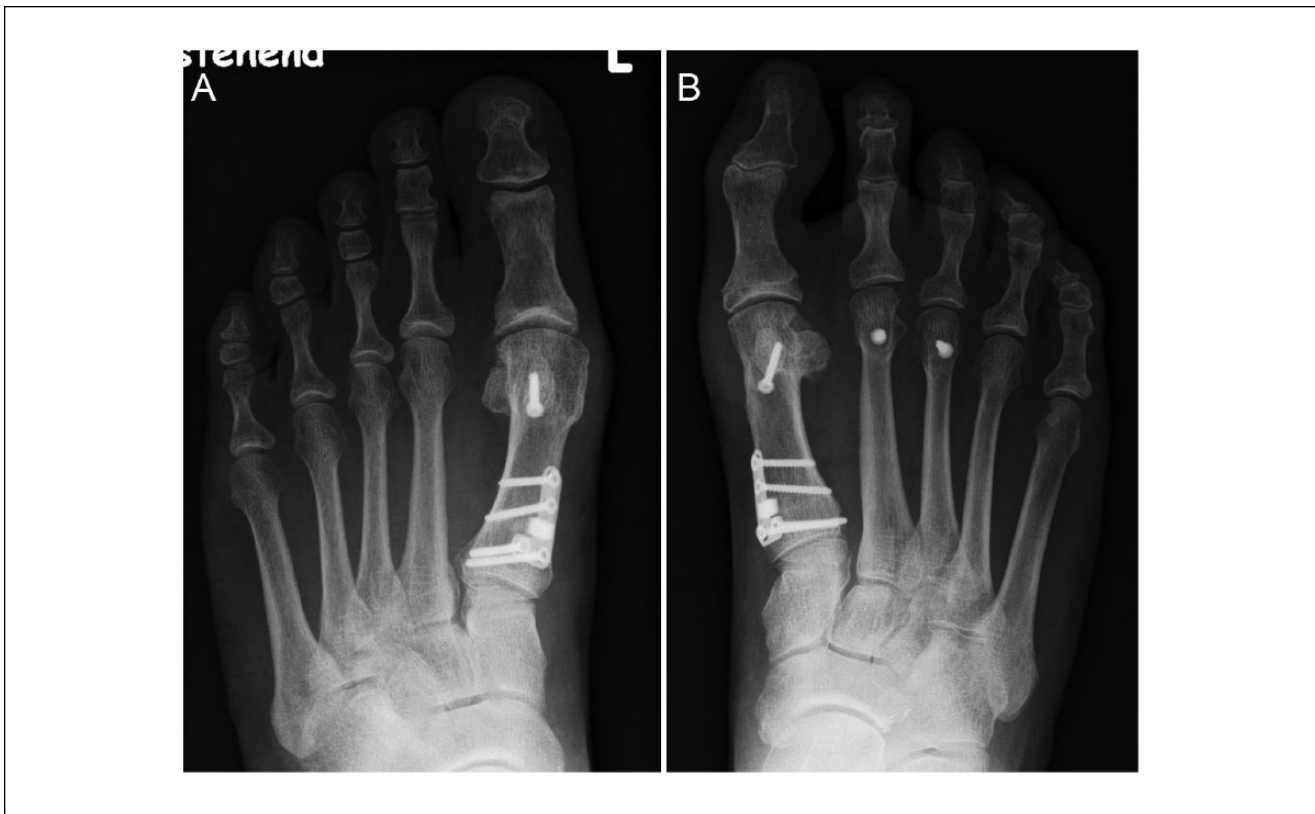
Various cases of 5-year postop X-rays of patients undergoing isometric technique.
